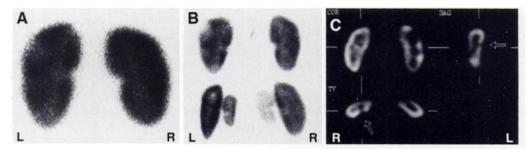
Multifocal acute pyelonephritis of the left kidney is clearly seen on both parallel-hole (A) and pinhole (B) images. A small lesion in the posterior aspect of the right kidney (arrows) was seen only on the SPECT (C).
